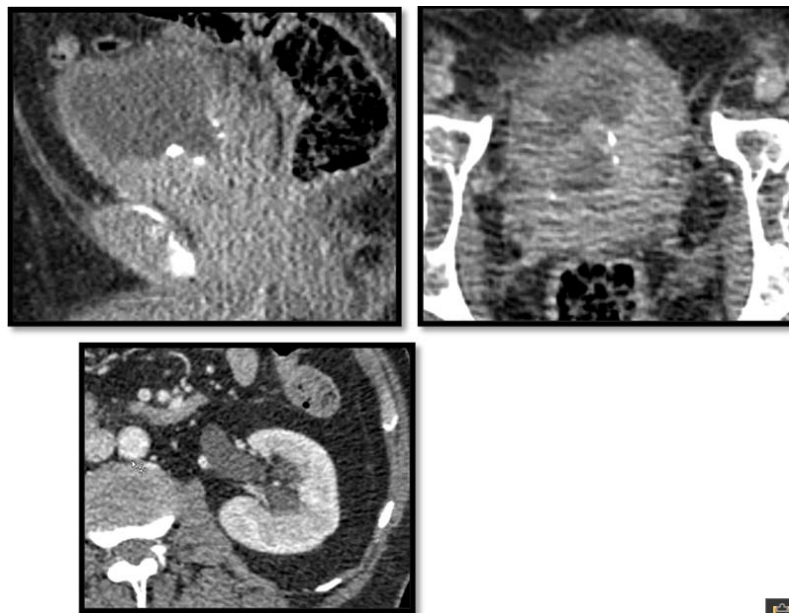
CT of pelvis with sagittal and axial reconstruction. Locally advanced prostatic cancer with bladder trigone and lateral wall invasion, responsible for moderate homolateral uretero-hydronephrosis.
